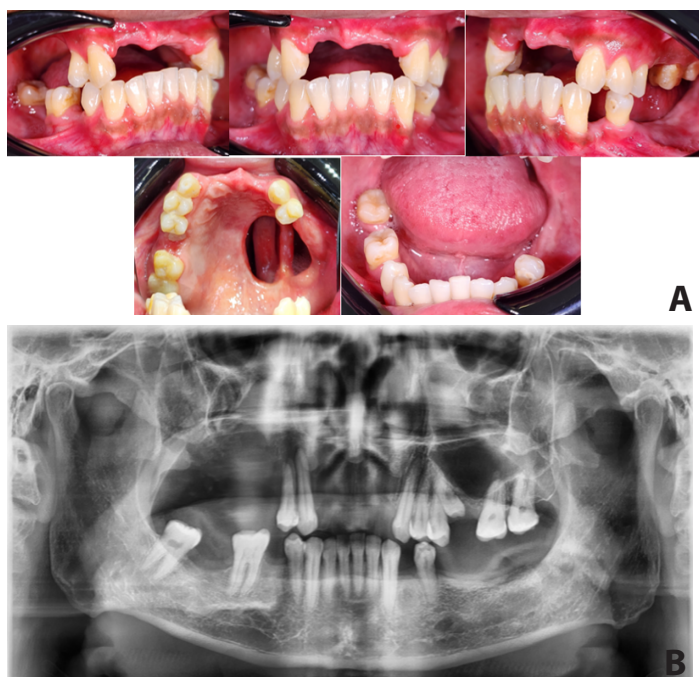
A. Intraoral examination, B. Panoramic radiograph
